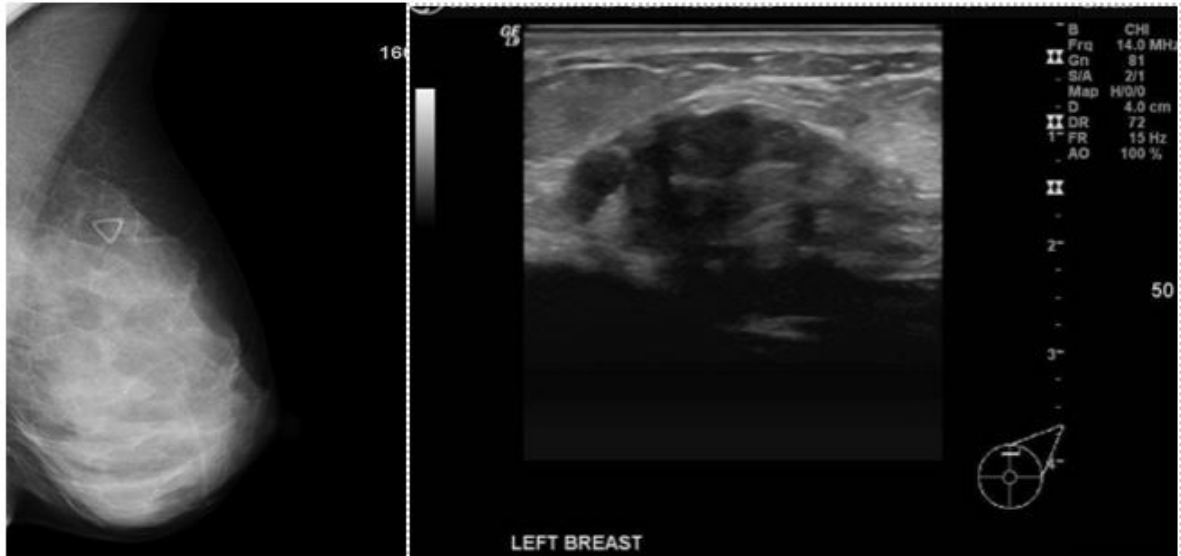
This mass was identified by ultrasound at the area of the palpable abnormality (marked with the triangular-shaped metallic marker on the mammogram obtained same day as ultrasound). It is completely obscured by dense breast tissue on the mammogram. Dense breast tissue obscures small masses and delays diagnosis.
